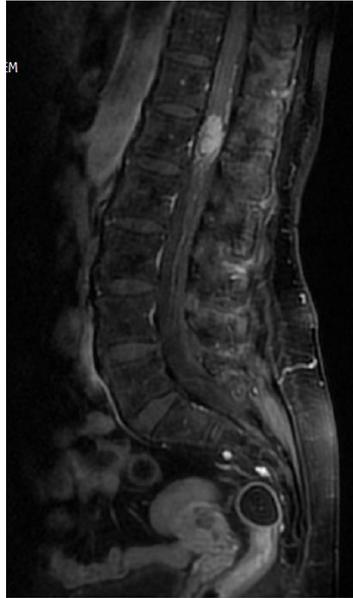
T1-weighted MRI image showing intramedullary metastasis of breast cancer to the spinal cord at Th12-L1 level – frontal view
